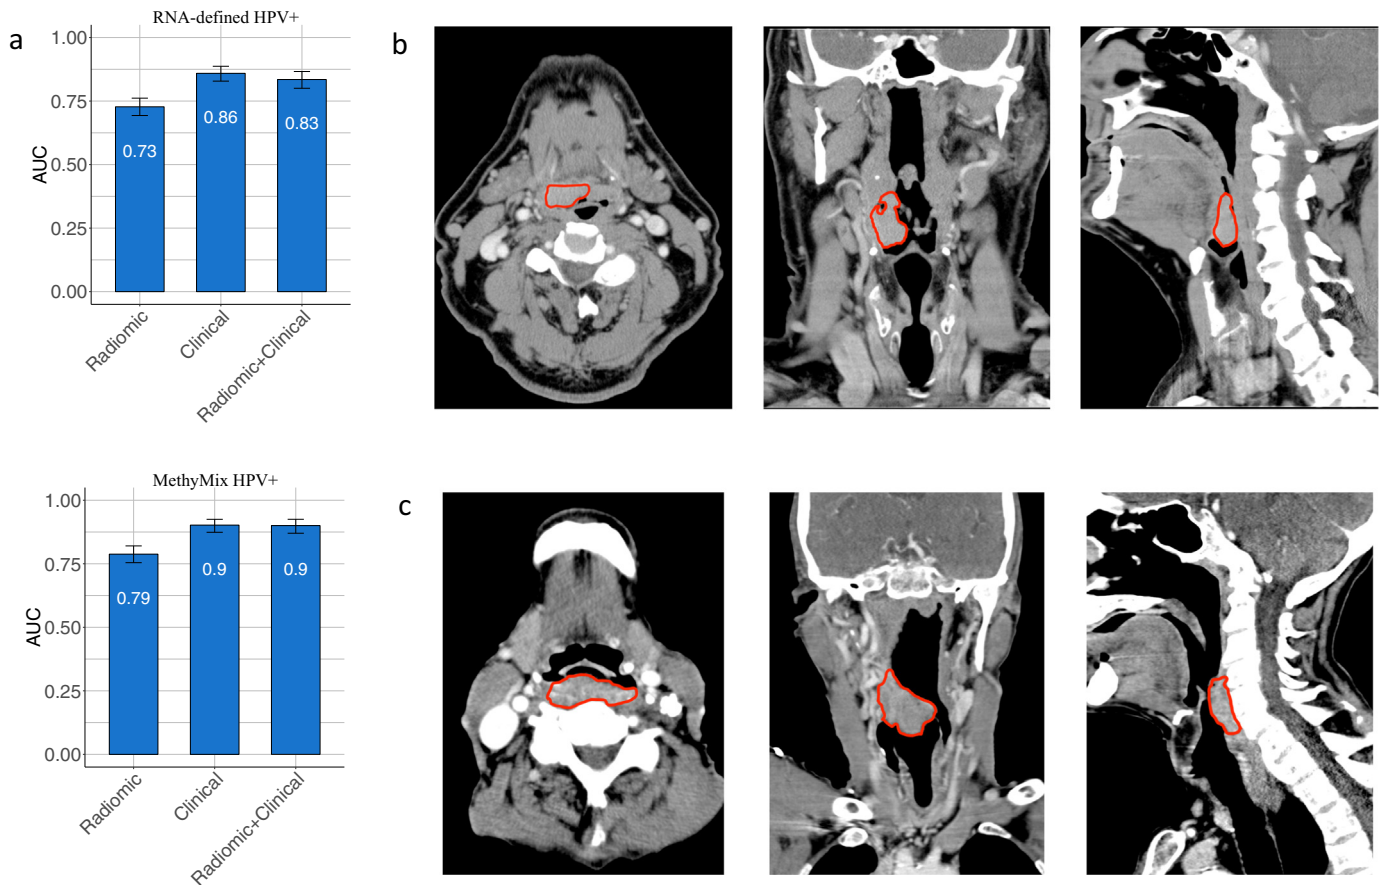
Prediction of HPV infection. (a) Prediction of HPV infection status and the DNA methylation HPV subtype. Each bar plot depicts the average AUC and the error bars represent the 95% Confidence Interval (CI) with 1000 bootstrapped resamples of the AUCs from the outer cross-validation loop. (b) Selected CT image of patient TCGA-CR-5250 who had an HPV positive tumor located in oropharynx. (images order: axial, coronal, sagittal). (c) Selected CT image of patient TCGA-BA-A41F who had an HPV negative tumor located in oropharynx. (images order: axial, coronal, sagittal).
